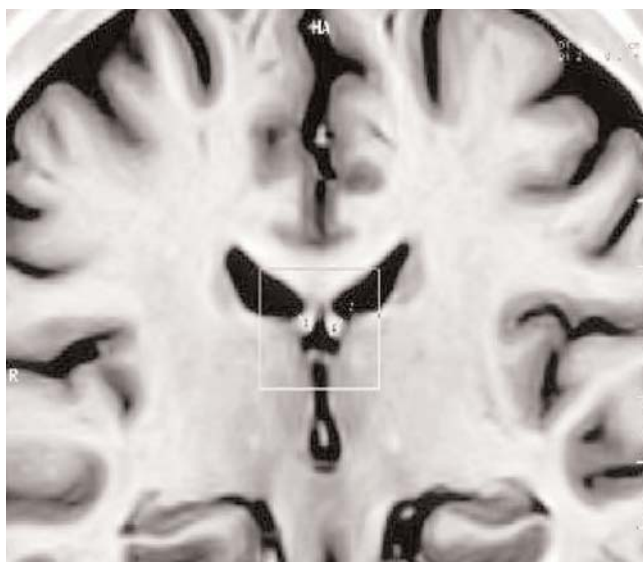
Fornix width measurement on a coronal section. From “Morphometry of some elements of limbic system in normal population: a quantitative MRI study” by Yücel K, Hakyemez B, Parlak M, Oygucu IH. *Neuroanatomy* 2002;1:15–21.^[33] © neuroanatomy.org. Reprinted with permission.
